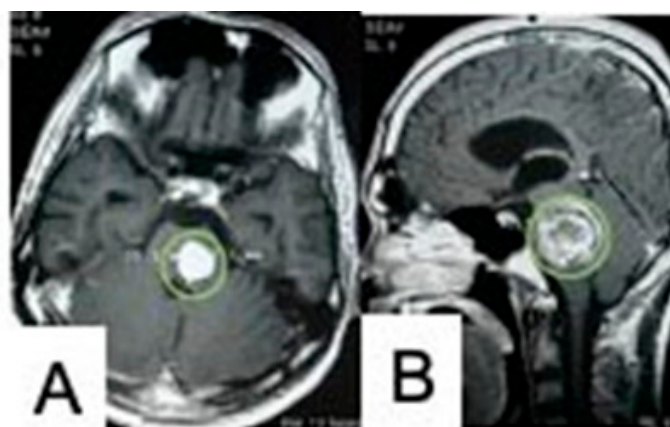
MRI of brain axial (A) and sagittal (B) view showing a CM in the posterolateral pons with a halo sign. Source: Figure by authors.
